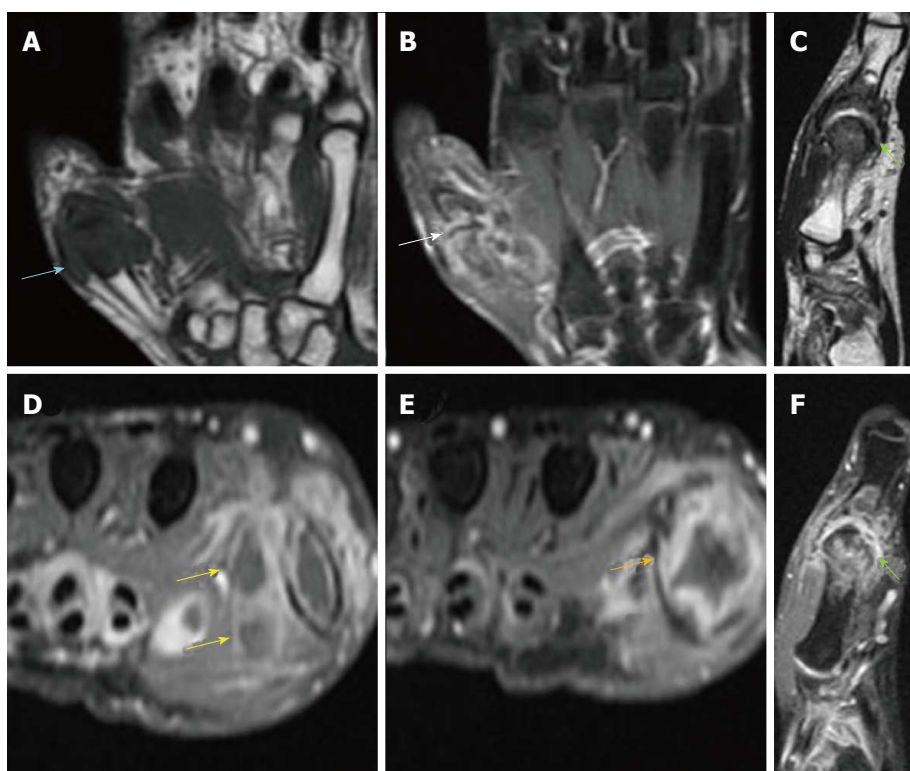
Plain and contrast enhanced magnetic resonance imaging images of proximal hand. A: Coronal T1W. Hypointense soft-tissue is noted surrounding the first MCP joint with hypointense marrow changes; B: Coronal STIR. Irregular hyperintensities are seen surrounding the first MCP joint along with hyperintensity within the peri-articular bone marrow; C: Sagittal T2W. Mild joint effusion is seen with hypertrophied T2 hypointense synovium and pannus formation; D-F: Axial and sagittal post-contrast Fat Sat T1W. Arrows indicate peripherally enhancing abscesses adjacent to the first MCP joint. Also noted in the vicinity is enhancing proliferative pannus. MCP: Metacarpophalangeal.
